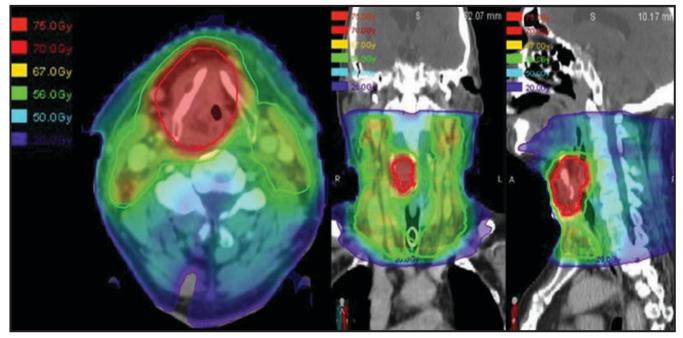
Axial, coronal and sagittal CT images with an overlying dose-grid demonstrate the treatment plan used for this patient. The red outline represents the 70 Gy isodose line, and the green outline represents the 56 Gy isodose line. Other dose levels are indicated on the color legend.
